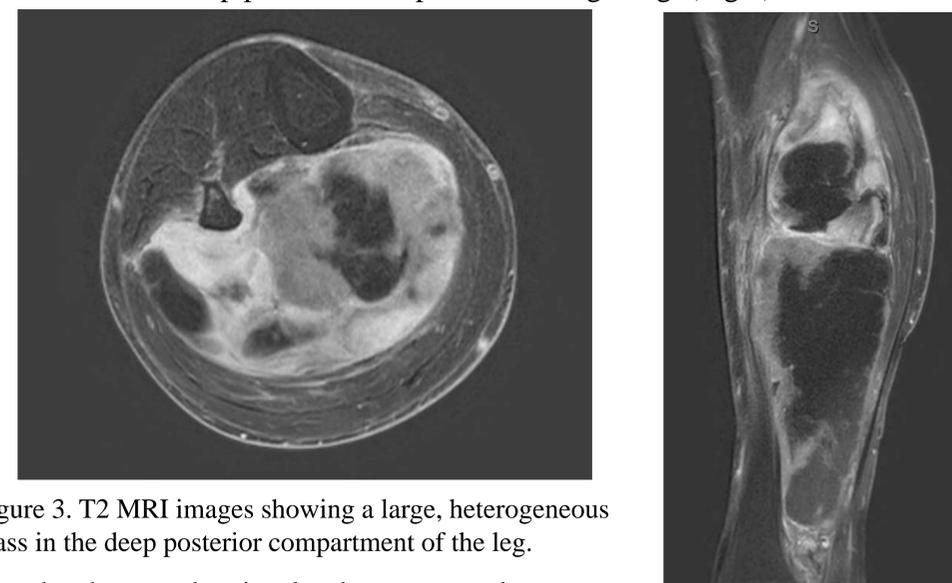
T2 MRI images showing a large, heterogeneous mass in the deep posterior compartment of the leg.
